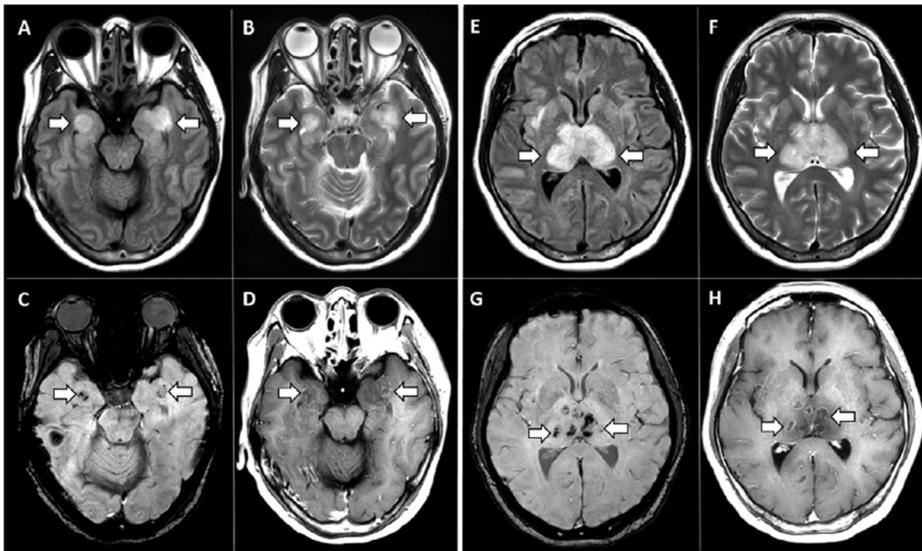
The MRI scan of a patient with COVID-19 showed evidence of bleeding. T2 FLAIR hyperintensity was observed in the paired medial temporal lobes and thalami (A, B, E, F), and the hemorrhage was identified by a hypointense signal intensity on susceptibility-weighted images (C, G). Additionally, post-contrast imaging revealed rim enhancement (D, H) (reprinted with permission [108]).
